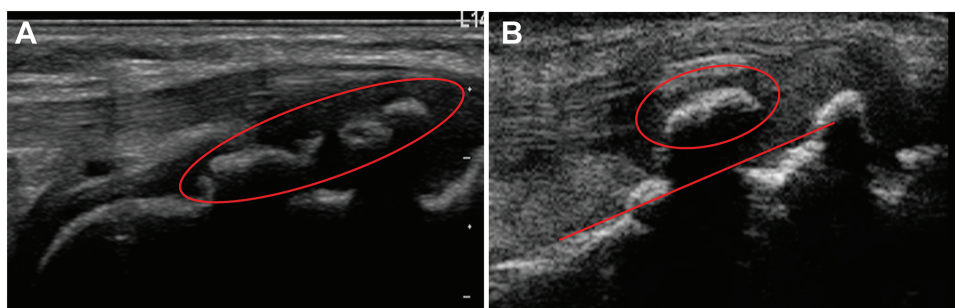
Ultrasound images showing morphological abnormalities of the tibial tuberosity. (A) Irregular: segmented secondary ossification (circled). (B) Avulsion: separated secondary ossification (circled) from the tibial tuberosity (indicated by line).
